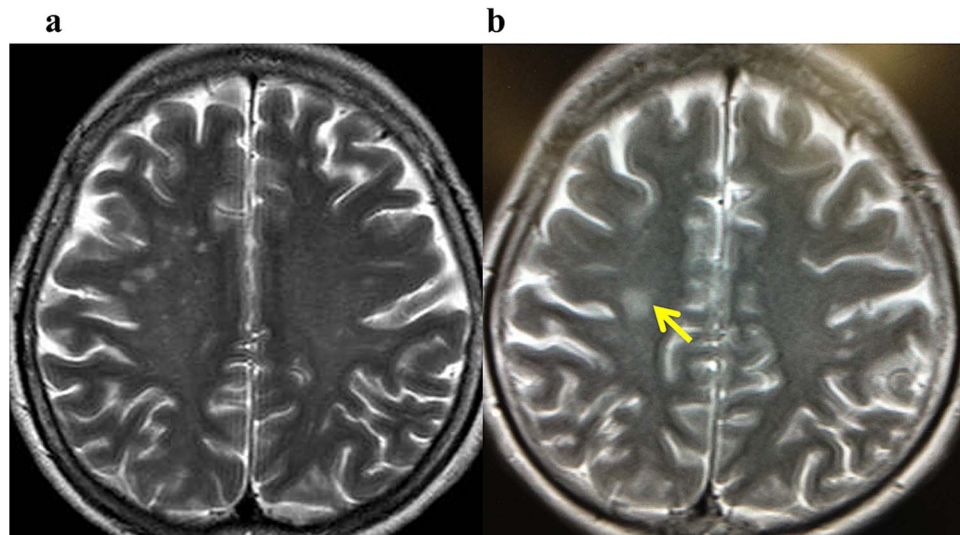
Recurrence vasculitis with metal allergy after the patch test. (a) T2 weighted magnetic resonance image after treatment with steroid before the patch test. (b) T2 weighted magnetic resonance image shows small nodular high intensity lesions (↑) as recurrence vasculitis with metal allergy after the patch test.
